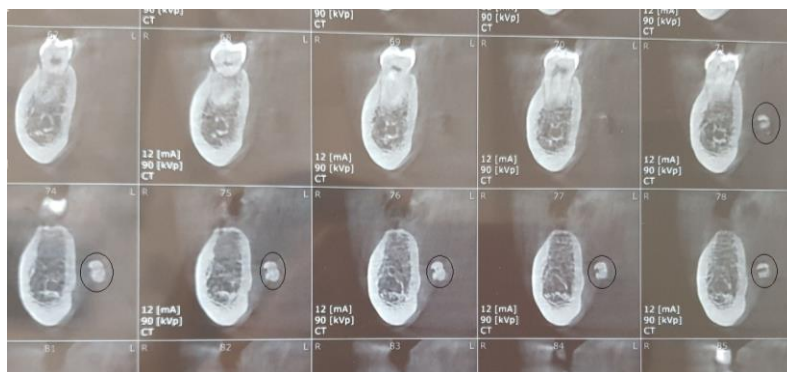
CBCT showed the presence of an oval calcified structure with cement-like radio opactiy
